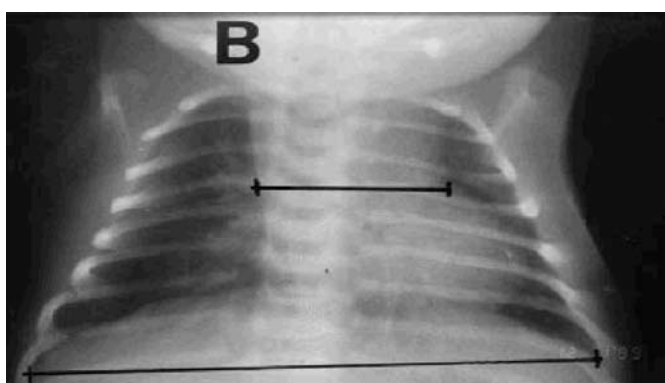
The CT/T is calculated as a ratio of the cardiothymic shadow at the carina divided by the width of the thorax at the costophrenic angle.
